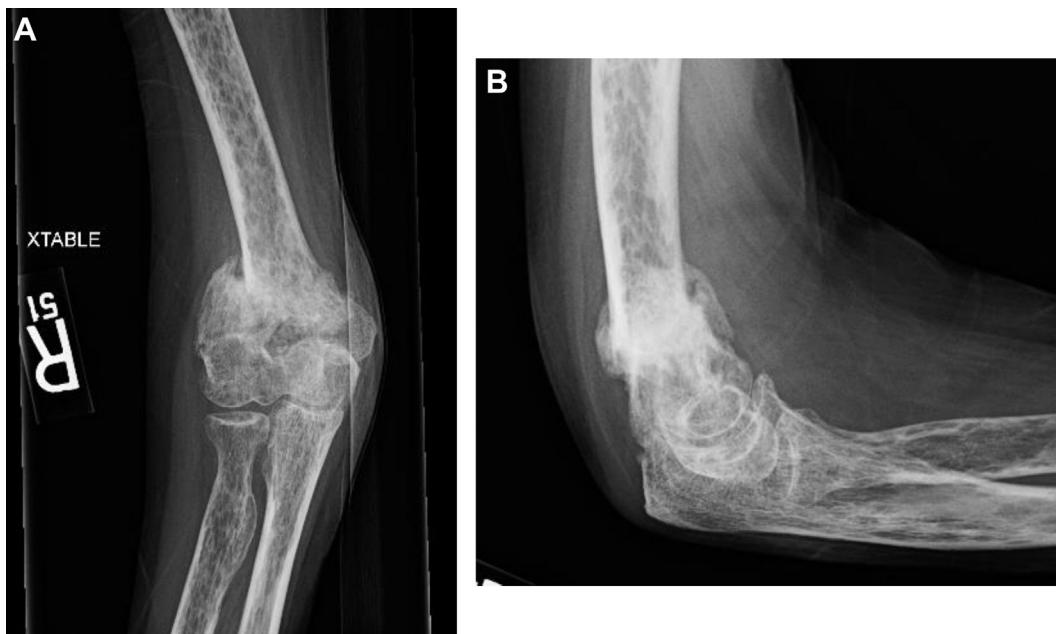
Case 1: A 60-year-old woman with radiographs at 3-month visit. Elbow ROM was 10° to 95°, supination 20°, pronation 90° at the 3-month visit.
